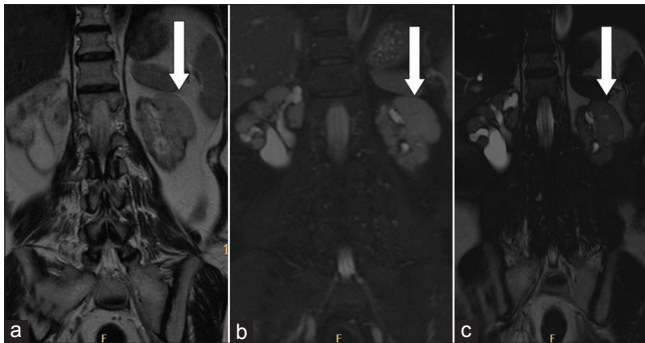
Coronal MRI sections T2 (a), T2-fat saturation (b) and balanced fast field echo (c) show a partly exophytic lesion in the mid pole of left kidney showing the same signal as the rest of the renal parenchyma (white arrows). Both kidneys appear shrunken with nodular surface and mild hydronephrosis
